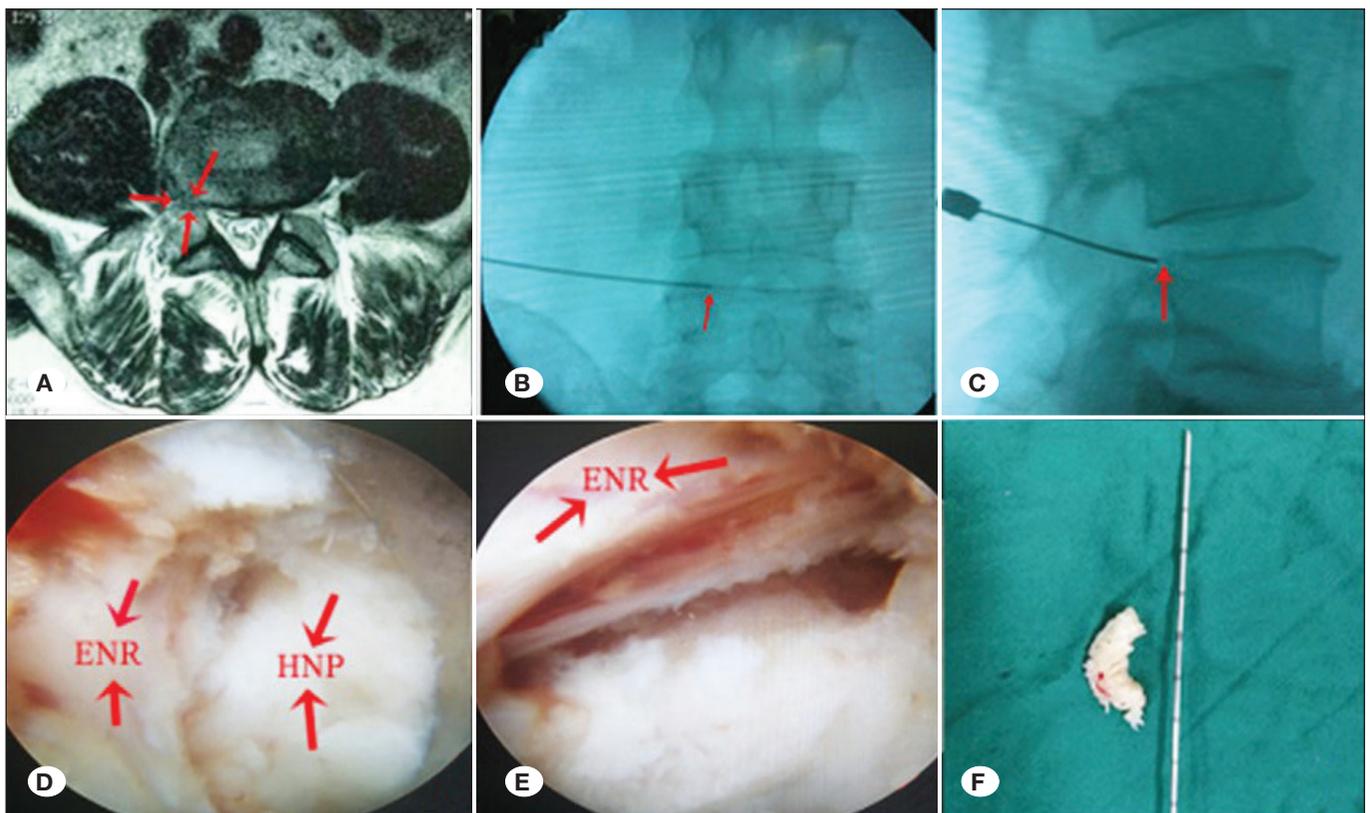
Imaging results showing a small-size herniated nucleus pulposus (HNP) of a male patient (63 years old) experiencing extremely serious pain with. A) Small-size HNP (red arrow). B) Location of the needle tip in antero-posterior X-rays. C) Location of the needle tip in lateral X-rays. D) Exiting nerve root (ENR) and HNP at the ventral side of ENR. E) ENR after sufficient decompression. H) Protrusions obtained during PETLS.
